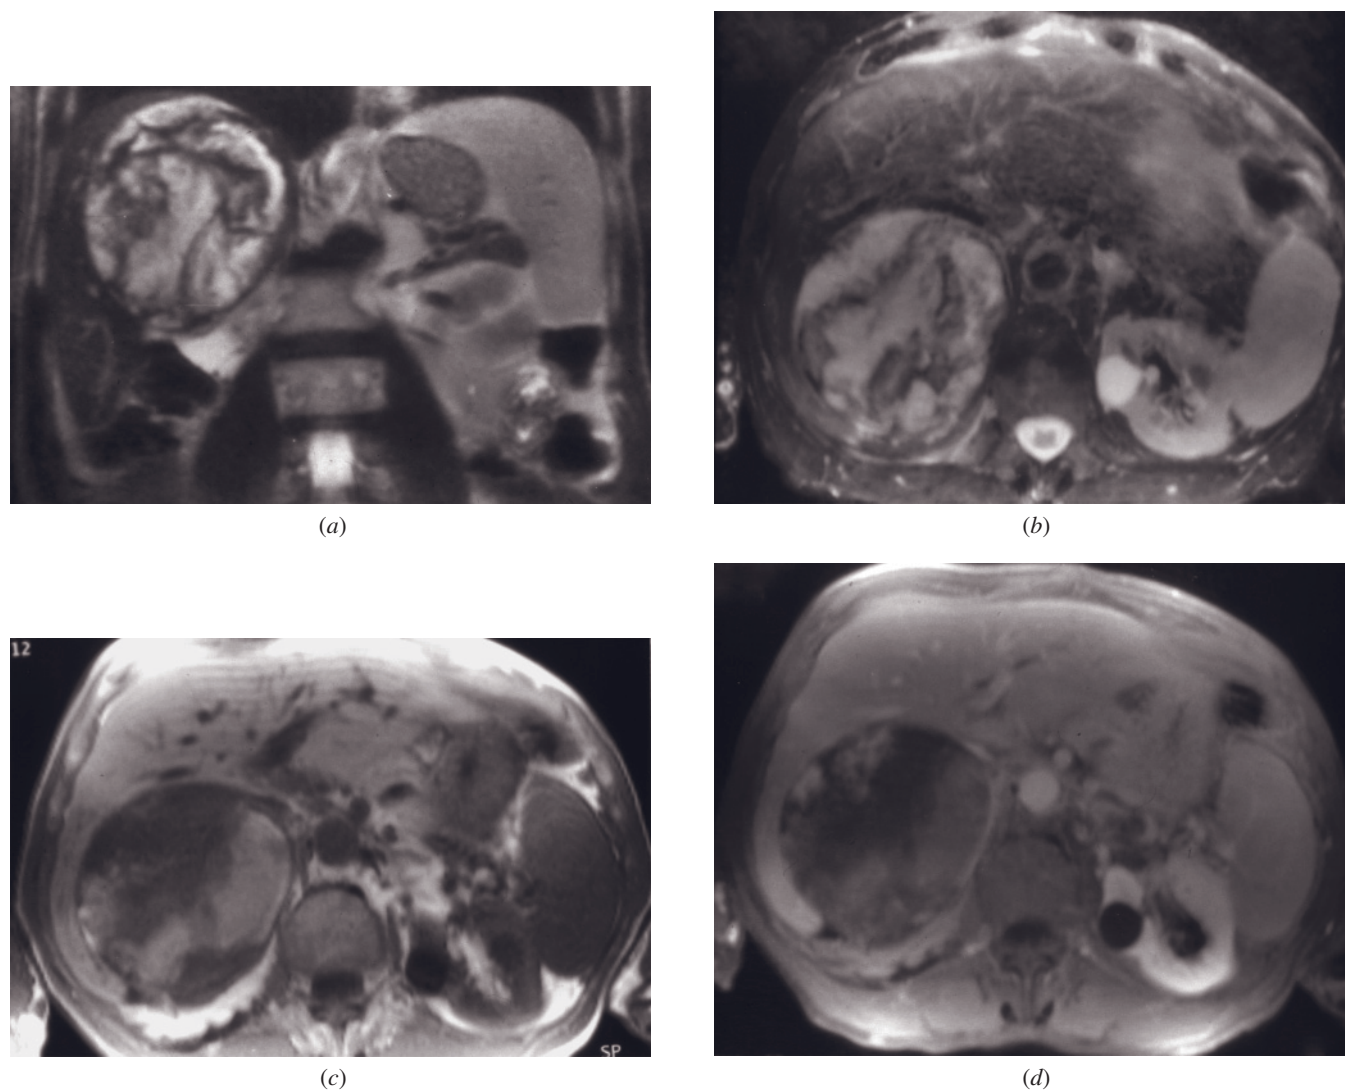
Adrenal hemangioma. Coronal single-shot echo-train spin-echo (*a*), T2-weighted fat-suppressed echo-train spin-echo (*b*), T1-weighted GE (*c*), and 2-min gadolinium-enhanced fat-suppressed GE (*d*) images. A 10-cm mass is present arising from the right adrenal that is mixed signal on T2 (*a*, *b*)- and T1 (*c*)-weighted images, consistent with hemorrhage. Small peripheral nodules of enhancing stroma are appreciated on the postcontrast images (arrow, *d*). Adrenal hemangiomas have a great propensity to undergo hemorrhage and appear as a large hemorrhagic mass.
